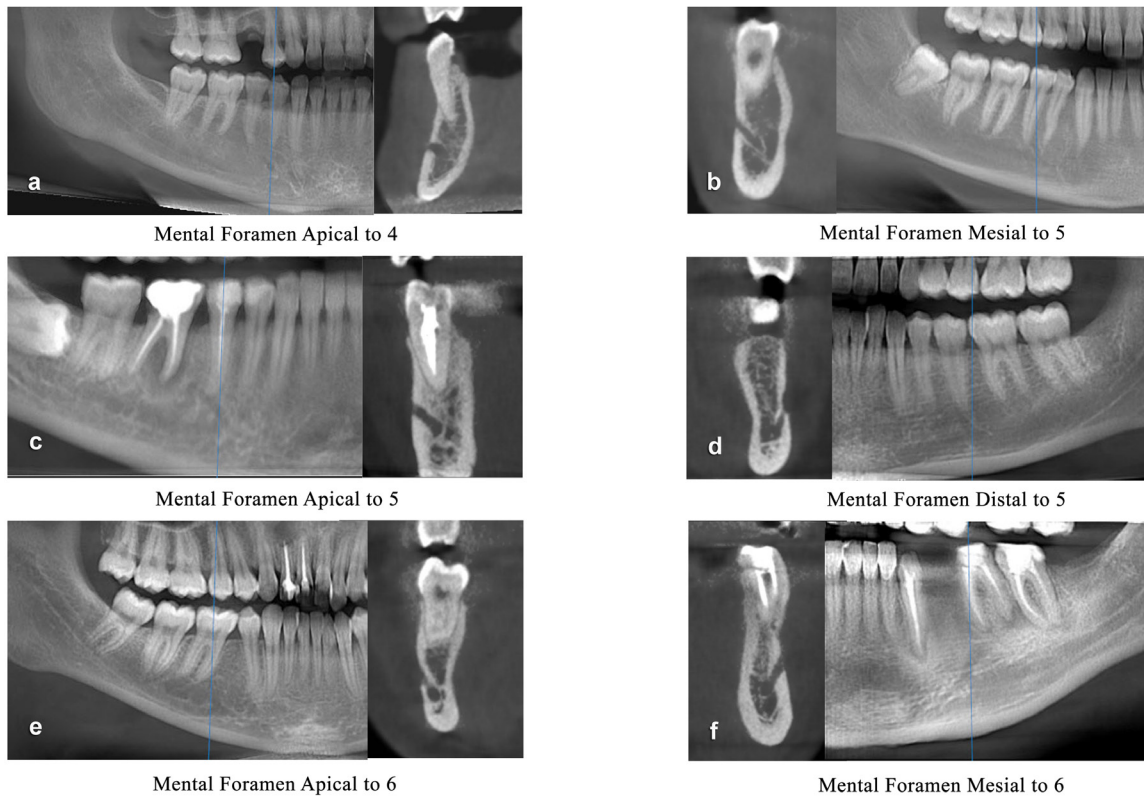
CBCT images of the mandible showing the variable positions of the mental foramen and its relation to the lower teeth.
